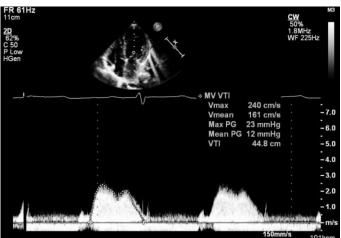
Continuous-wave Doppler echocardiogram across the stenotic mitral valve showed Vmax of 240 cm/s and mean Pressure Gradient of 12 mm Hg.
